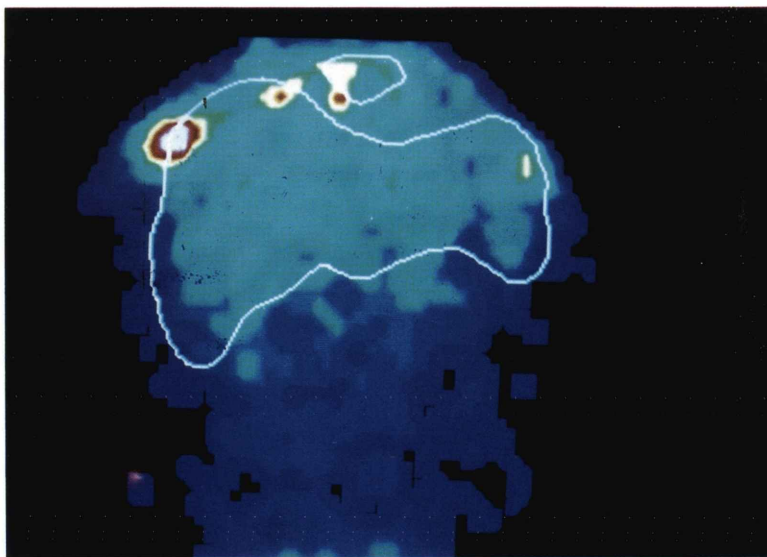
Immunoscintigram with "radioimmunococktail" 3 days after injection: solitary metastasis of liver in a patient with colorectal carcinoma.
